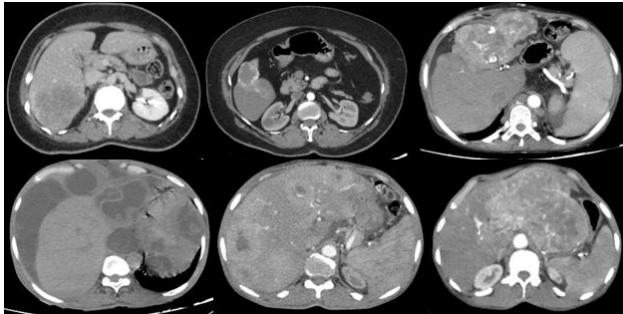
Abdominal CT images
